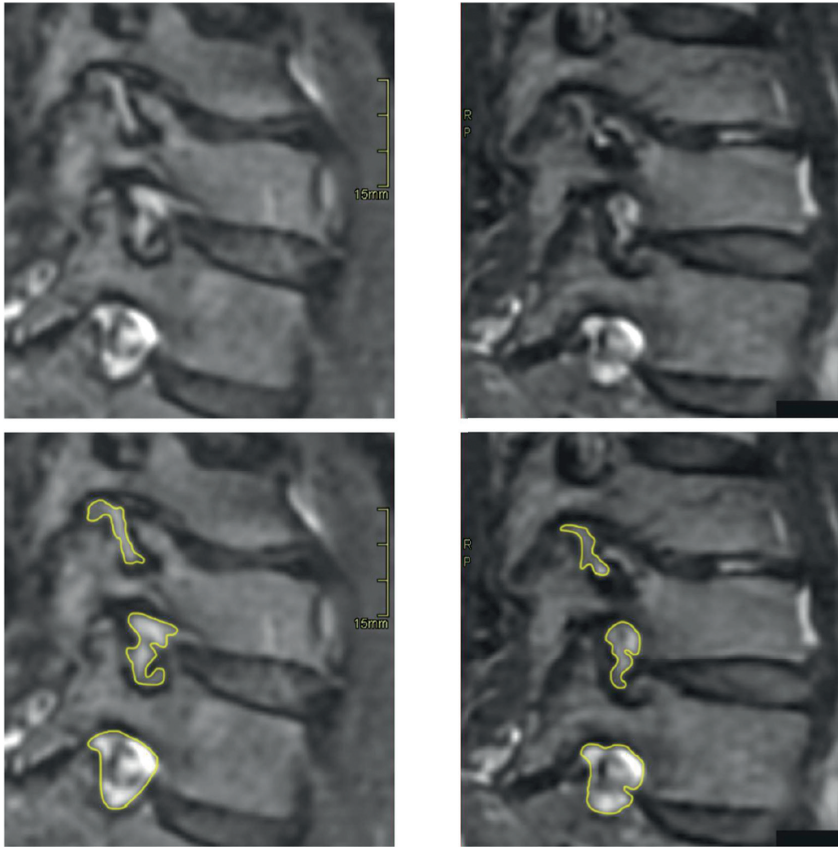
The left images present one patient in the relaxed state, while the right images were captured during the Spurling test of the same patient. The demarcated foraminal area is indicated in the images below. *Figure 2 from “Cervical Foraminal Changes in Patients with Intermittent Arm Radiculopathy Studied with a New MRI-Compatible Compression Device,”* by Hutchins J et al., published by MDPI in J Clin Med. 2023 Oct 12;12(20):6493. Licensed under CC BY.
